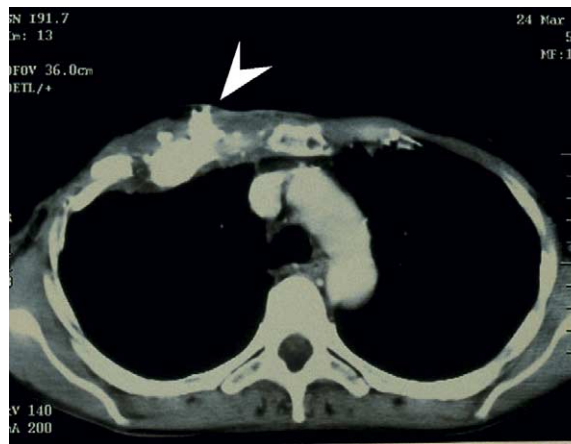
Chest CT-scan of the woman described in Fig. 1(A): costal lysis is combined with aberrant calcium depositions (arrow).
